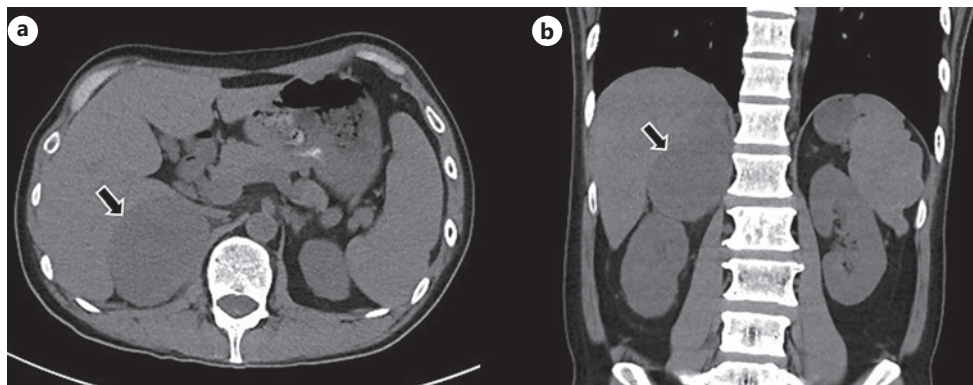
Noncontrast CT scan of the abdomen. Axial (a) and coronal (b) images show a low-density mass in the right adrenal gland (arrow).
